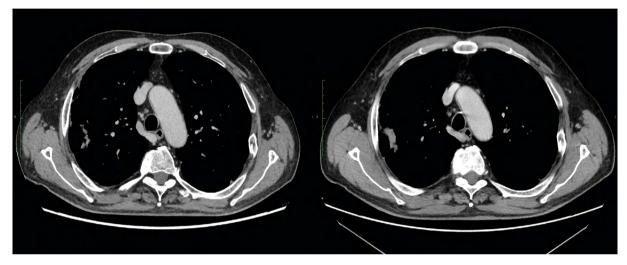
Computed tomography scans showing no progression despite stopping immunotherapy — Jan/Apr 2024
